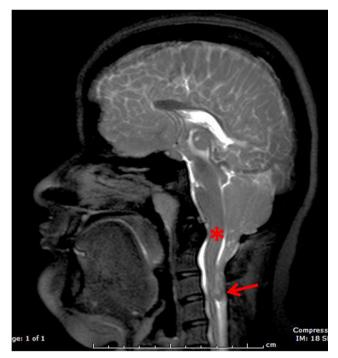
CNS malformation associated with open NTD. Sagittal T2weighted MRI of a teenager with a repaired open NTD and shunted hydrocephalus. The small posterior fossa is associated with a hindbrain herniation (Chiari II) with downward displacement of the cerebellum and brainstem. The cerebellar tonsils extend to C4 (*arrow*) and the medulla is in the cervical canal (*asterisk*). Migration abnormalities can be present to a varying degree in both hemispheres leading to malformation of the lamination and gyral pattern. It would appear that the loss of CSF from the open NTD in utero produces the changes noted secondary to lack of distention of the neurocranium during development
